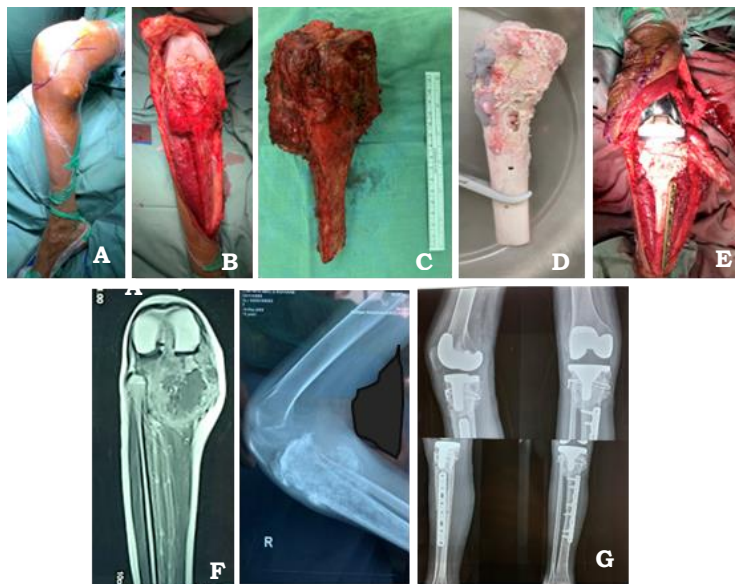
A. clinical photo of a 15-year-old female with osteosarcoma involving the proximal part of the tibia with knee joint involvement. B. Intraoperative view of the tumor. C. Post-resection of the tumor. D. Post-submersion in liquid nitrogen. E. Post internal fixation and total knee replacement; F. Radiomaging of preoperative state. G. X-ray imaging post internal fixation and TKR.
